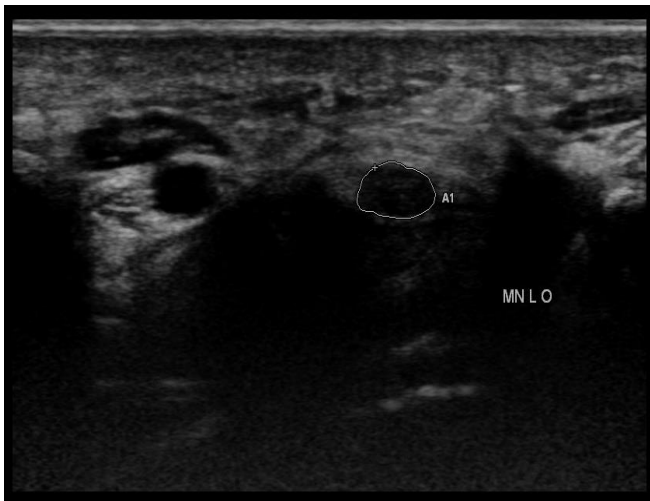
High resolution ultrasonography image of median nerve in the carpal tunnel in DPN patients: Nerve appears hypoechoic and thickened with increase in cross sectional area (circled).
